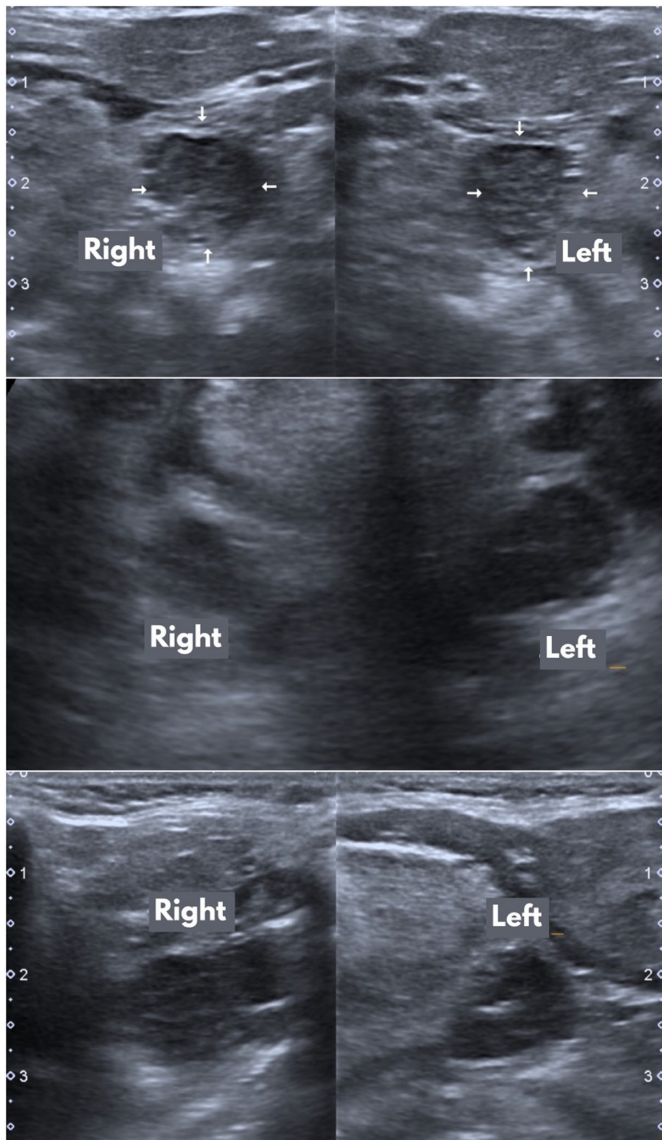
Sonographic image of palatine tonsils of 3 different patients.
